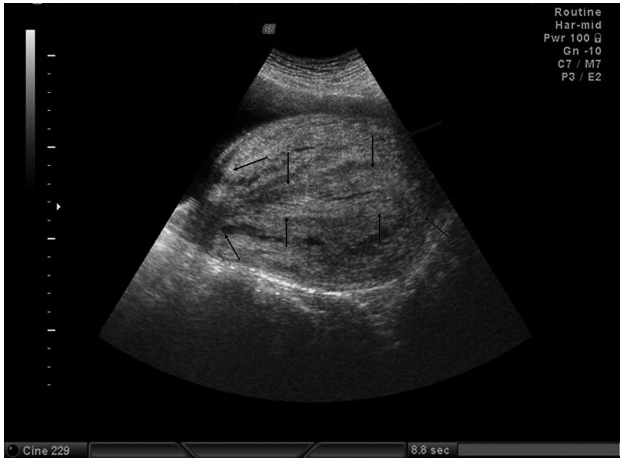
Ultrasound images of the uterus in the sagittal plane showing the inverted fundus turned 180 degrees (arrow).
